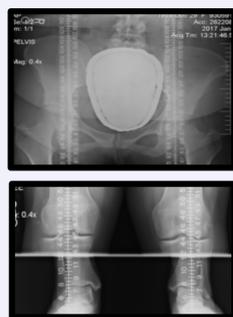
Preoperative radiographs of pelvis. Right pelvic length measures 4 mm longer than left. 2.1 cm right iliac tilt. Preoperative radiographs of ankles. Right ankle height is 5 mm higher than left. The right leg measures 1.2 cm longer than the left. Total leg length of femur and foreleg 16 mm greater on the right than left. Total leg length to include ankle height 19 mm greater on the right than the left.
